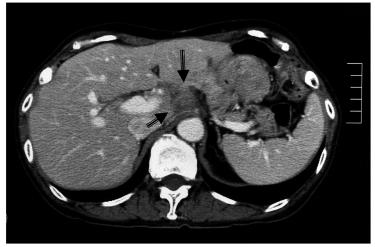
Abdominal CT performed on May 13, 2003.
